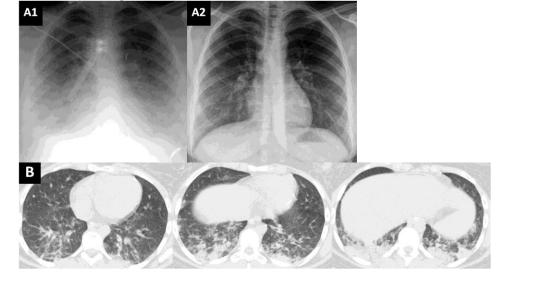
9th patient in the table: Bilateral reticular-alveolar consolidation opacities and daily (1st and 2nd) response to treatment were seen in figure 4A. HRCT images (reticular-alveolar consolidation opacities) at hospital admission and response to treatment were seen in figure 4B.
